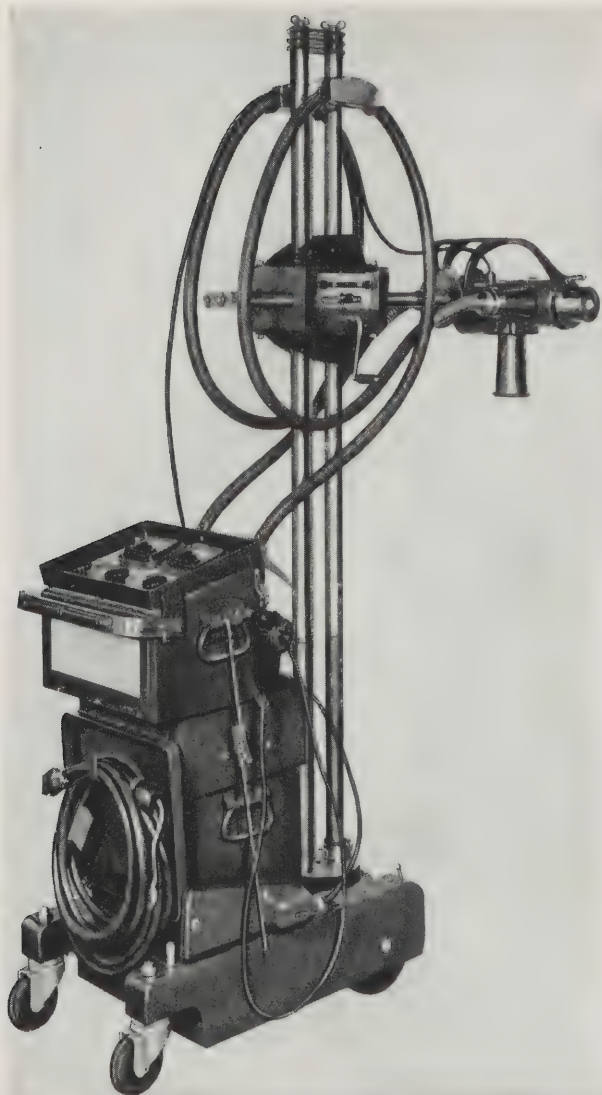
(a). Item 96085 assembled with Item 96090 showing adaptation as a mobile X-ray machine unit.
